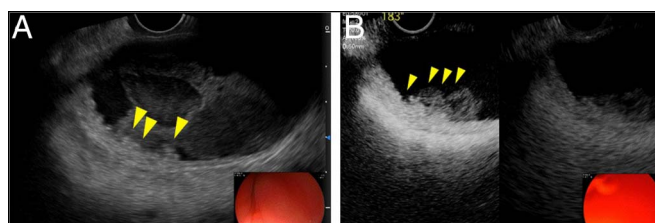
(A) Endoscopic ultrasonography demonstrated a high-echoic wall thickening and mass lesion with the papillary surface in the gallbladder body. (B) Contrast-enhanced endoscopic ultrasound revealed hyperenhancement and inhomogeneous enhancement pattern within gallbladder wall thickening and mass lesion.
